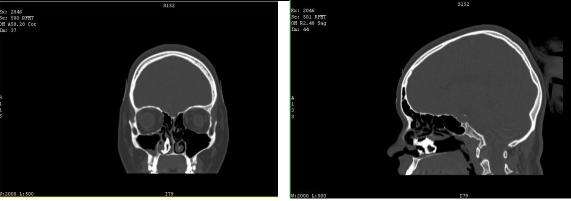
CT scan of PNS showed rhinolith in the Rt nasal cavity.
